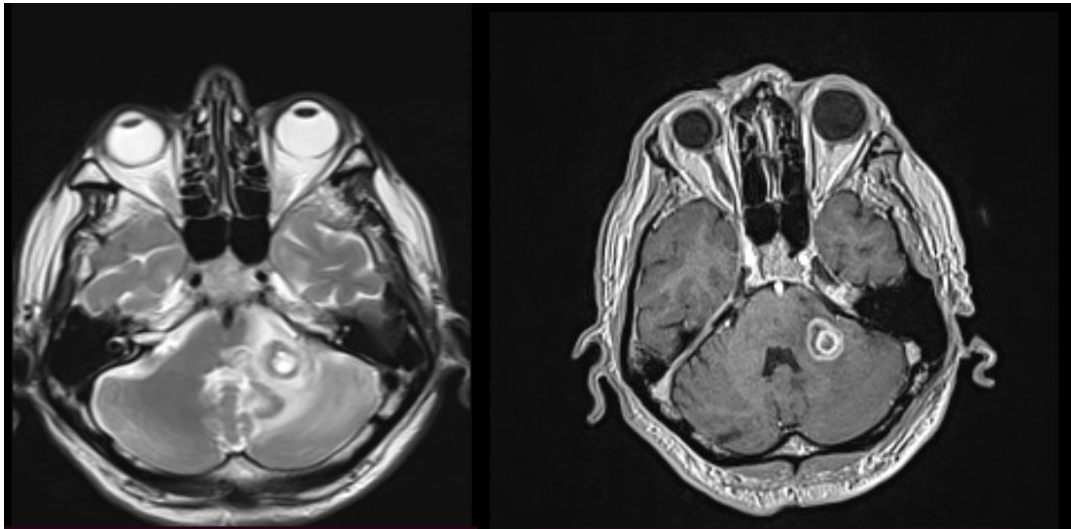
MRI scans of the brain with i.v native and postcontrast series
